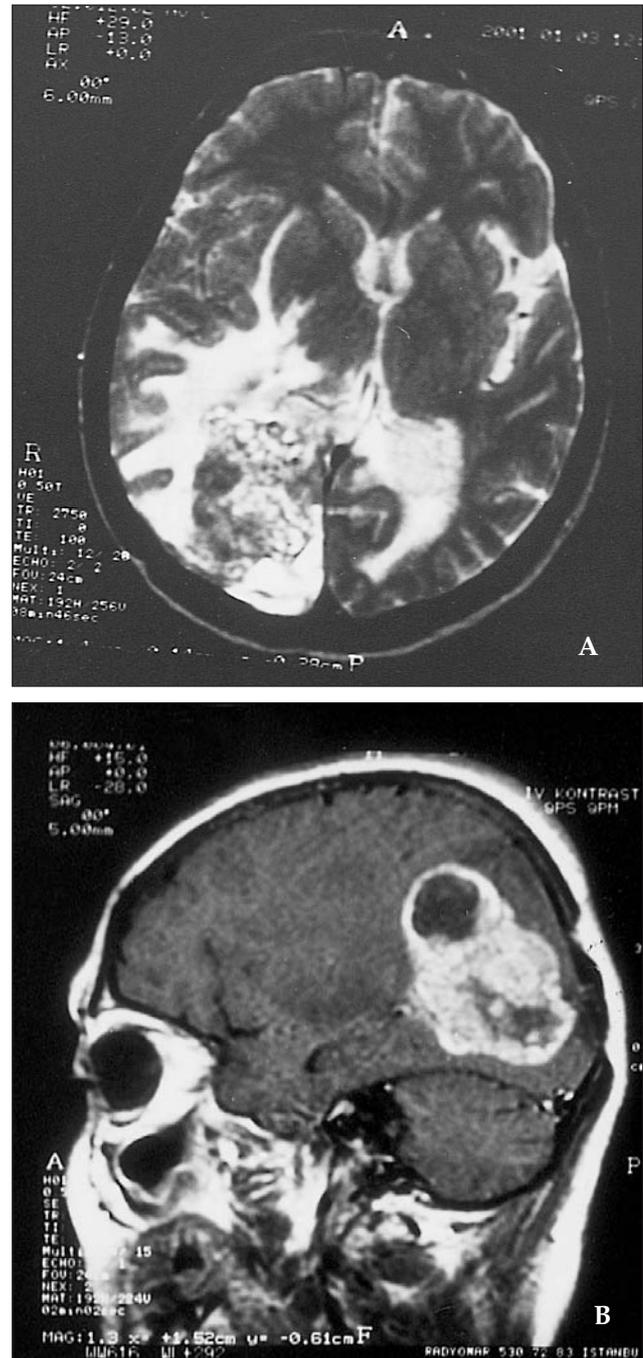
Axial T2-weighted (A), and sagittal T1-weighted (B) magnetic resonance sections of the patient.
